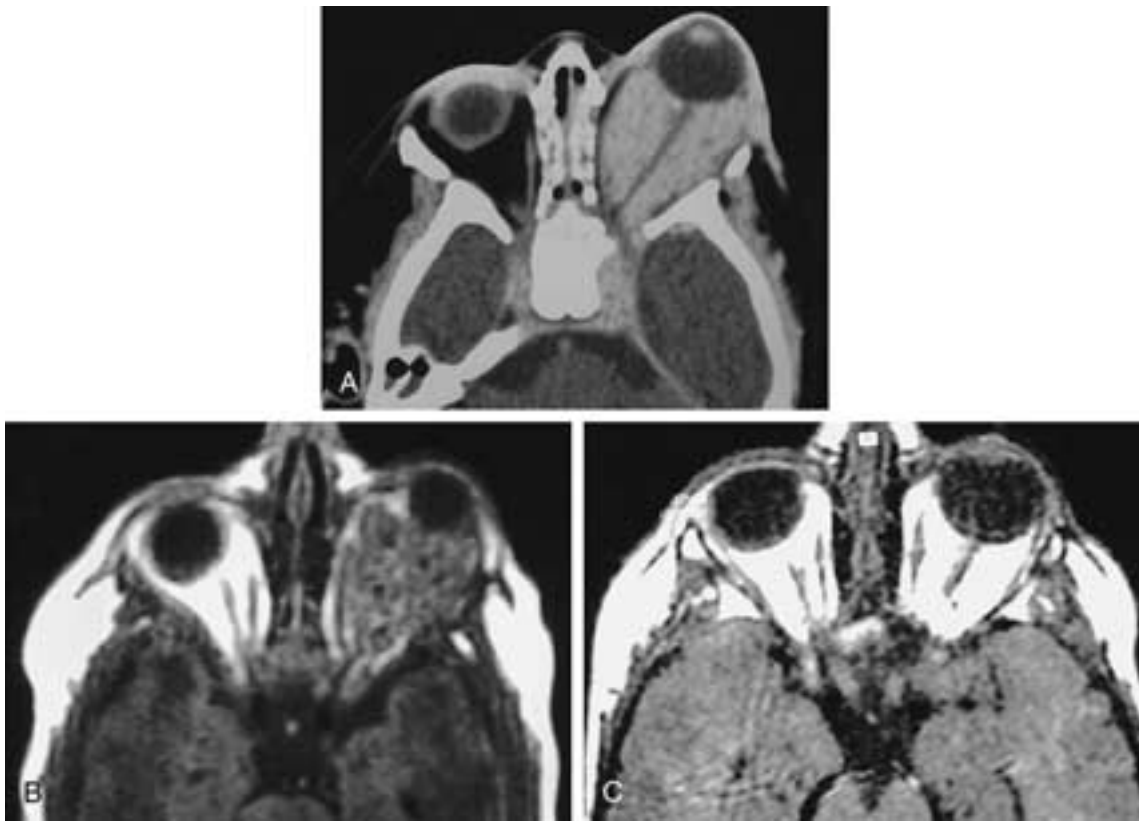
A baby boy with a left orbital capillary hemangioma that presented shortly after birth. A, Axial contrast-enhanced CT scan shows a mass filling and expanding the left orbit. The hemangioma appears to extend through the superior orbital fissure into the left cavernous sinus. The mass encircles and stretches the optic nerve sheath complex. Biopsy was performed but was inconclusive, and there was some discussion about further surgery. MR findings convinced the clinicians that this was a capillary hemangioma and the patient was treated with steroids instead. B, Axial T1-weighted MR image reveals a large, heterogeneous, finely lobulated mass expanding the left bony orbit. The focal regions of hypointensity are consistent with flow voids attributable to vessels. C, Axial T1-weighted MR scan shows that the capillary hemangioma involuted completely 2 years after the initial presentation. (From Bilanuik LT. Orbital vascular lesions: role of imaging. *Radiol Clin North Am* 1999;37:169–183.)
